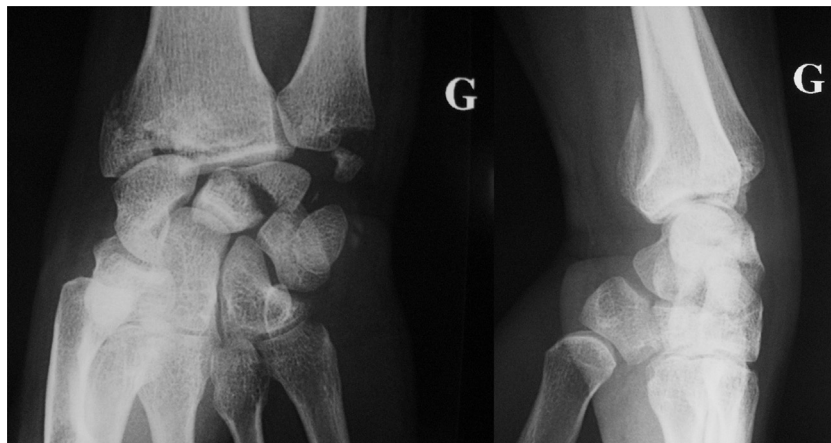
Standard preoperative A/P and lateral radiographs of the left wrist.
